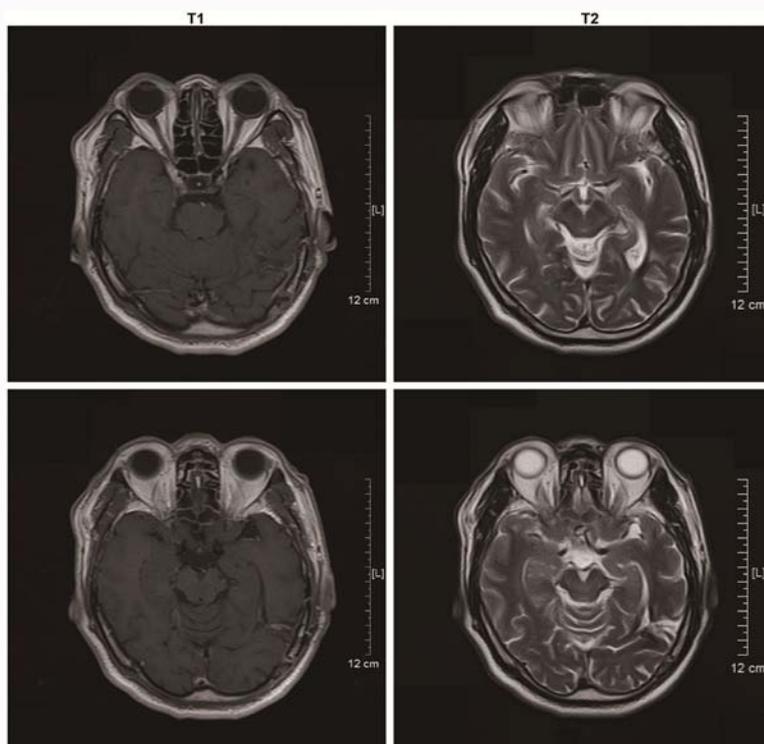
Postoperative MRI.
